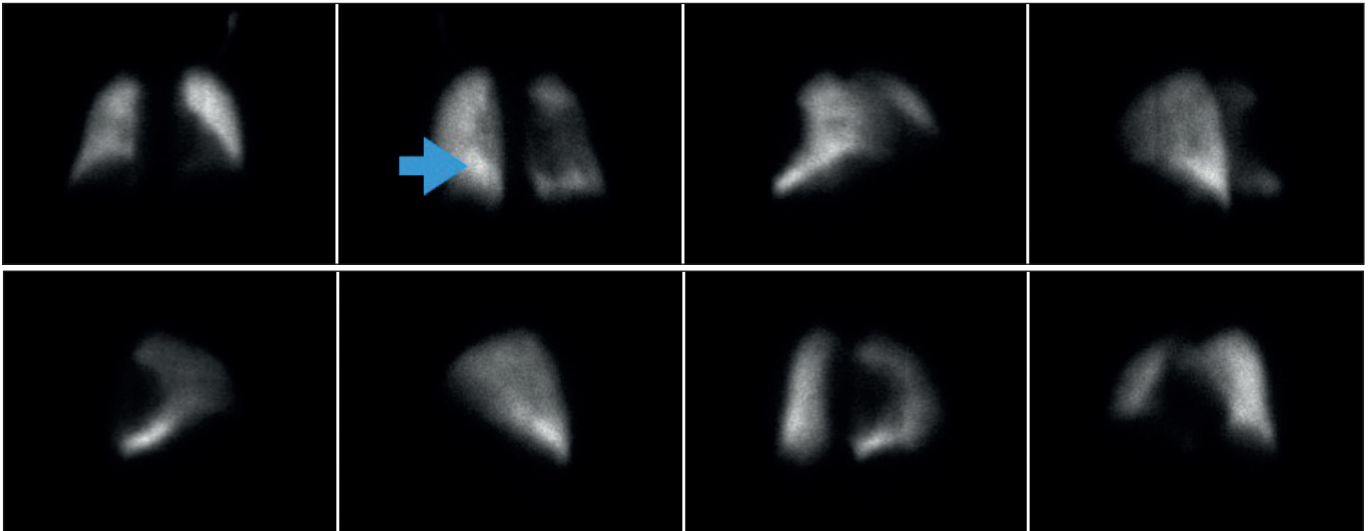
A patient with right basal segmentary perfusion defect on pulmonary scintigraphy.
